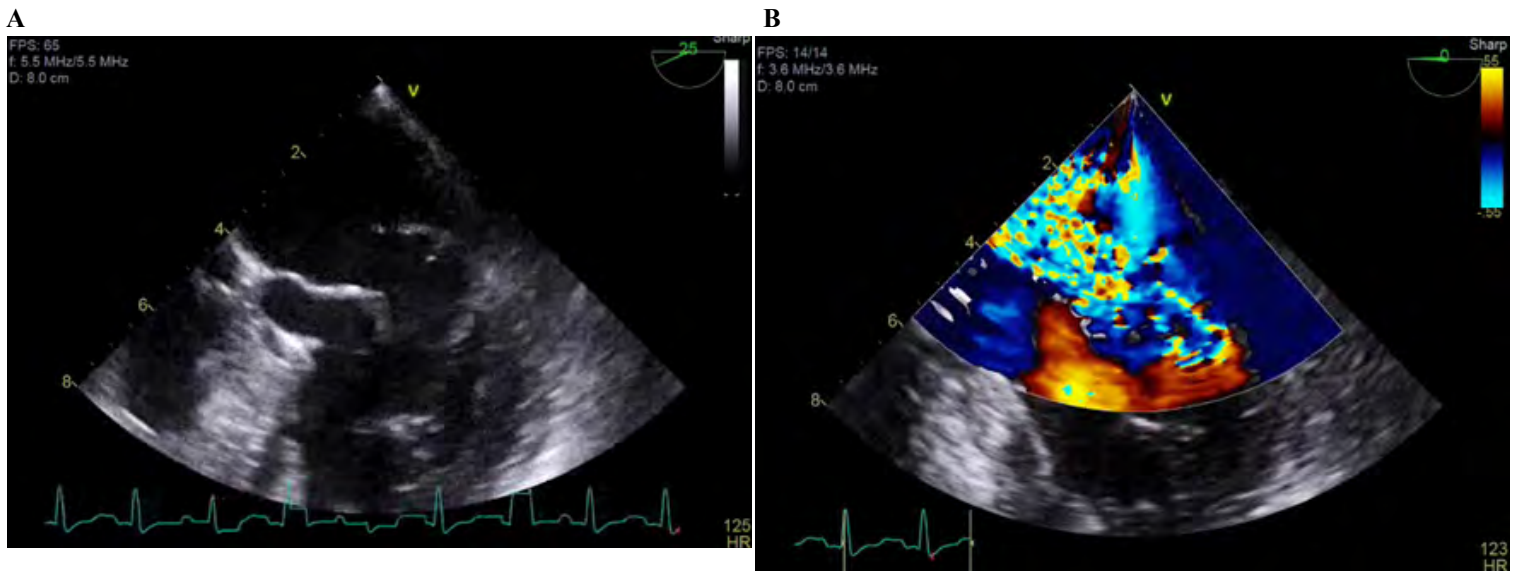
Mid-esophageal Four Chamber View on Transesophageal Echocardiogram
